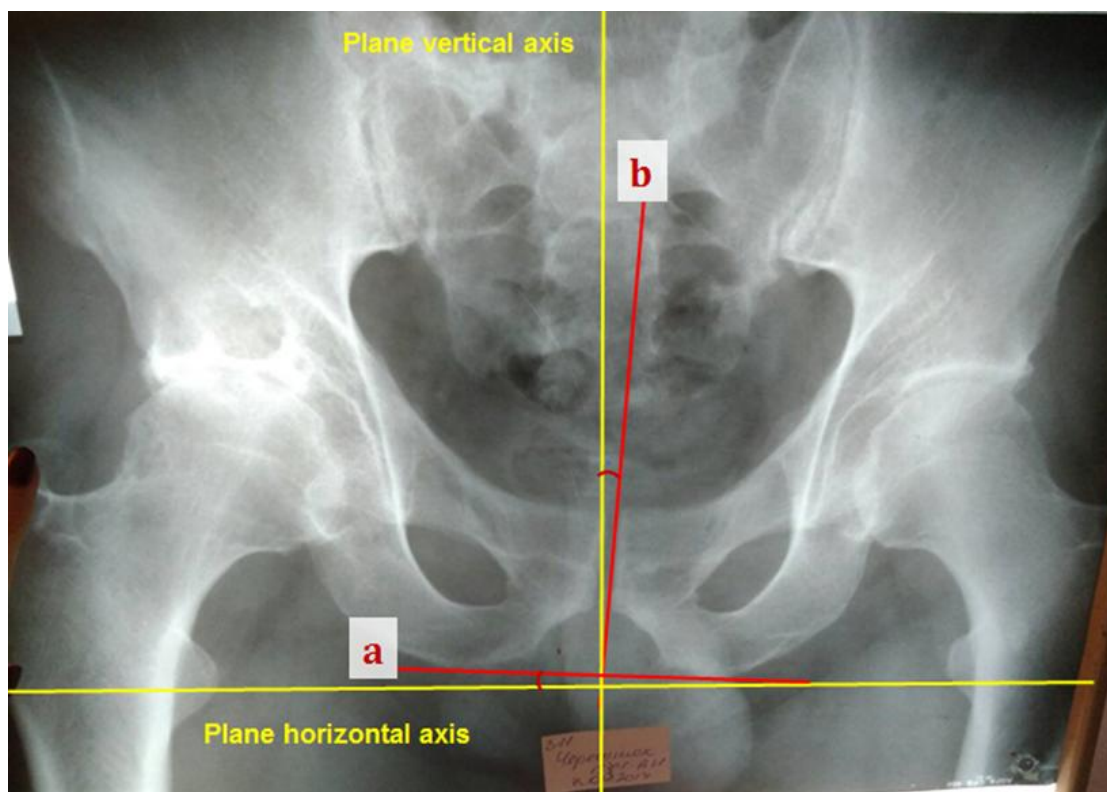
X-ray of sacroiliac and hip joints; a – horizontal axis of the pelvis, b – vertical axis of the pelvis
